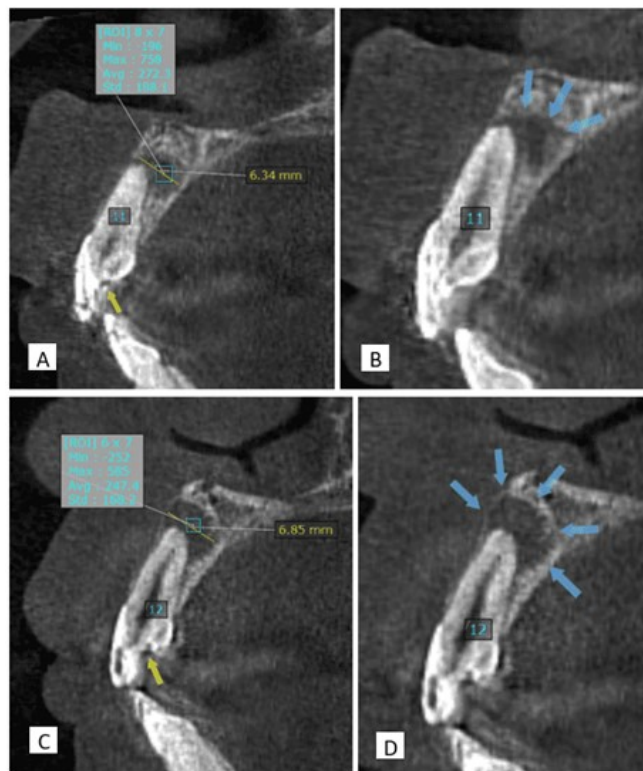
Sagittal view of the central upper right incisor (A, B) and lateral upper right incisor (C, D). Note the uneven border of the periapical lesion at the central incisor despite the perfect circular-shaped and corticated border at the lateral incisor, showing the “eggshell” thinning of the labial cortex caused by the lesion’s expansion (blue arrow)
